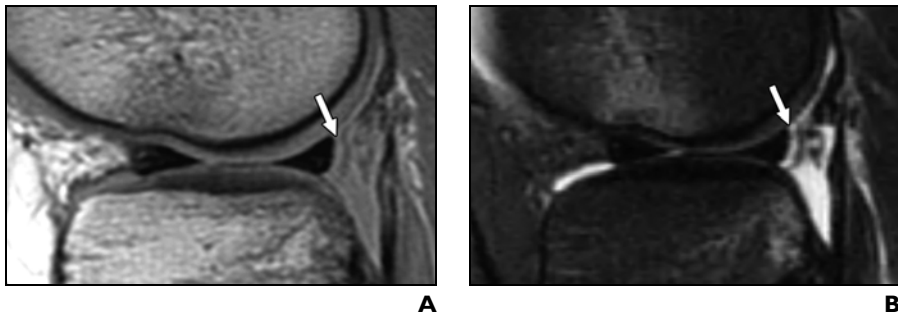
17-year-old girl with originally missed longitudinal peripheral tear of posterior horn of lateral meniscus seen on retrospective review. Tear was repaired with sutures. A and B, Sagittal fast spin-echo proton density-weighted (A) and sagittal fat-saturated fast spin-echo T2-weighted (B) images. Peripheral tear (*arrows*) is better seen on fluid-sensitive T2-weighted image than on proton density-weighted image. Prominent bone bruises are also seen in anterior aspect of lateral femoral condyle and posterior aspect of tibia in this patient who also had anterior cruciate ligament tear.
